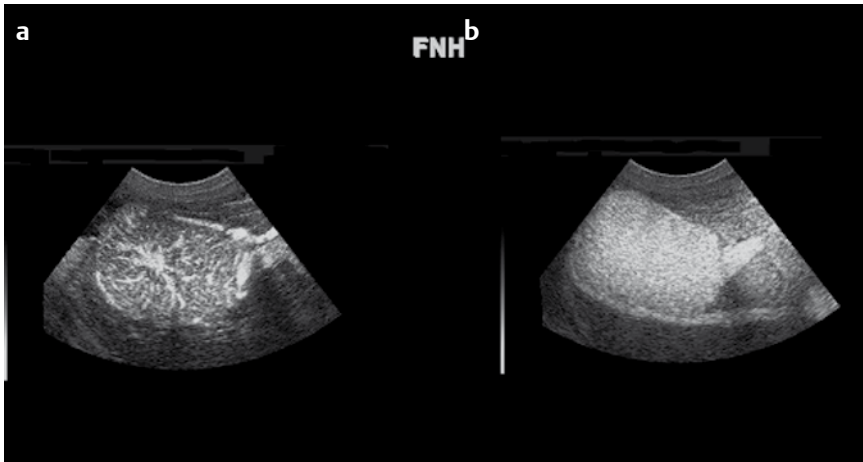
Key point 1 The examination of the hepatic arterial and portal venous and late phases by contrast-enhanced ultrasound allows for reliable differentiation between FNH and HCA. This important finding could be explained by the lack of portal veins in HCA, in contrast to FNH which presents arteries (a) and (atypical) portal veins (b).
